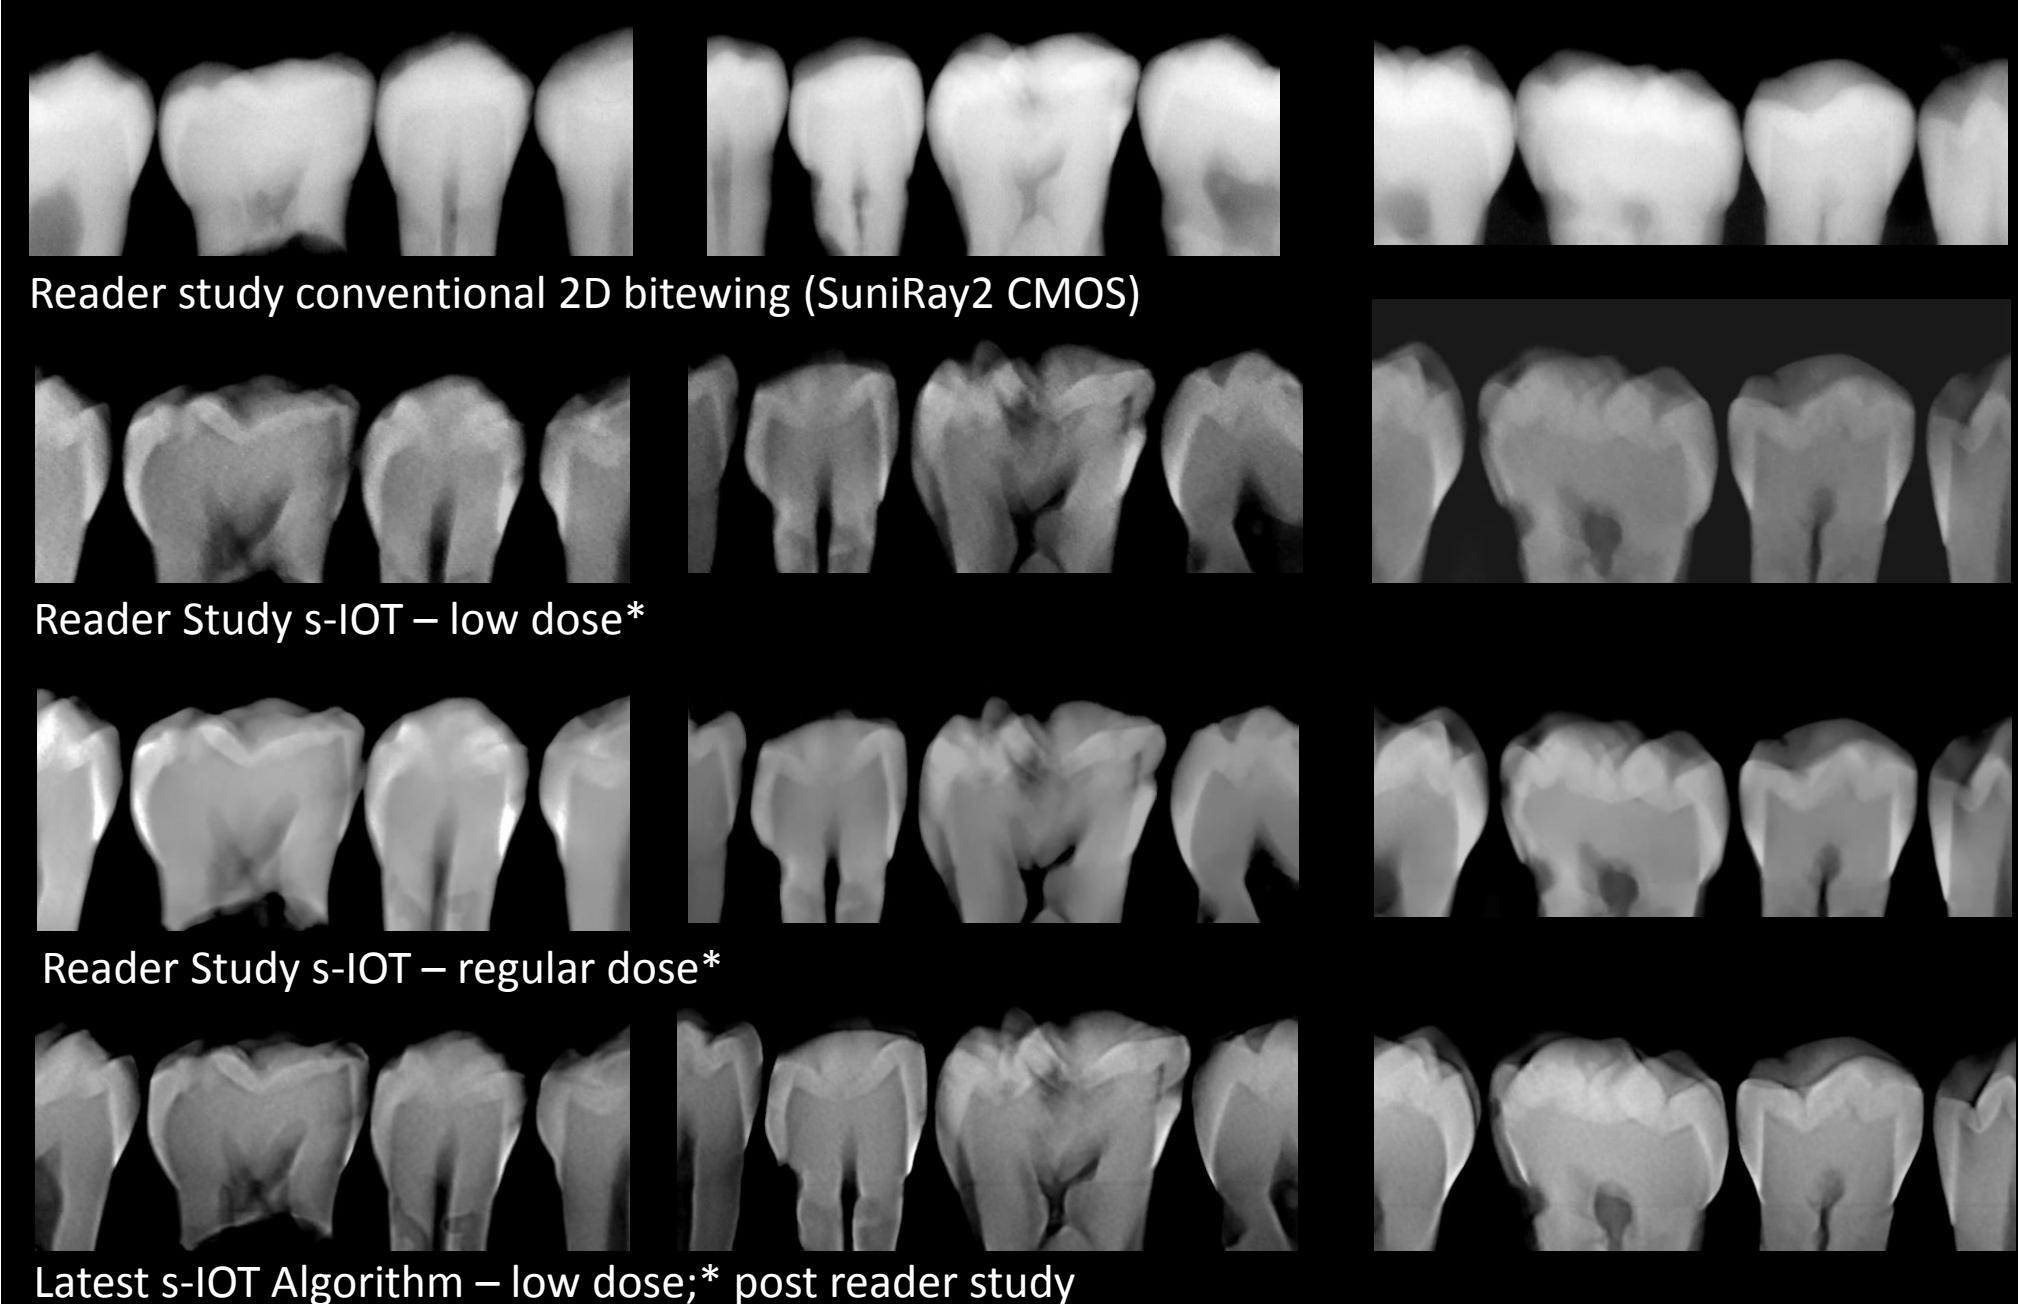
Comparison of 2D bitewing radiographs, s-IOT images at two different dose levels, and the latest reconstruction algorithm s-IOT images (post observer study).
